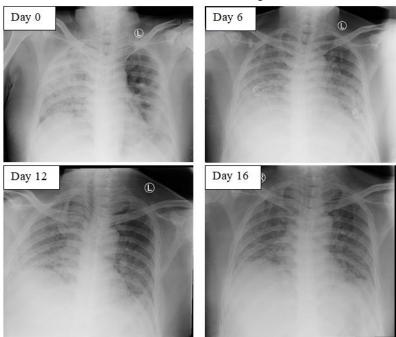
Serial chest x-ray showed lesser opacity in right supra-parahilar-paracardial and left parahilarparacardial on day 12 after receiving three times aaPRP treatments
